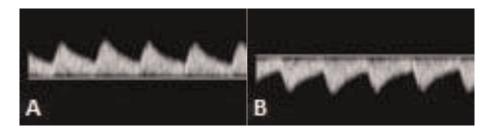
The Doppler curve of blood flow in the vessel. (A) Blood flow in direction toward the probe, (B) blood flow in direction from the probe.
